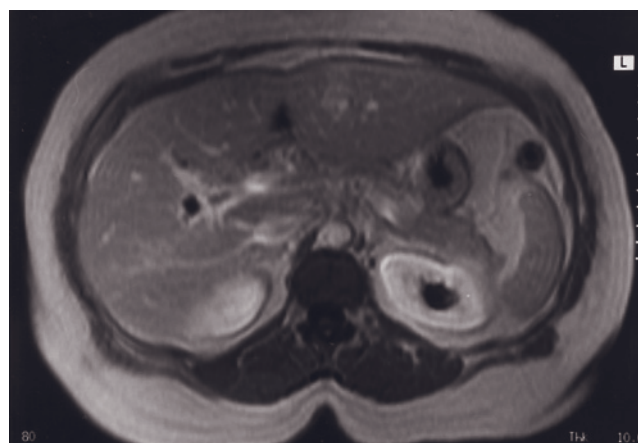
(Continued) an expansile thrombus (arrows, *a-c*) extending throughout the venous system. The thrombus demonstrates an increased signal intensity rim on T1-weighted images (*b, d, e*) and a small focus of increased signal intensity (arrow, *d*) within the thrombus, consistent with blood products at different stages of breakdown. Fat-suppressed postgadolinium images (*f, g*) demonstrate no evidence of enhancement within the thrombus. Thrombus is present in normal-caliber intrahepatic portal vein branches (arrows, *f*). Substantially increased enhancement of tissues surrounding the thrombosed SMV (arrow, *b*) suggests an underlying inflammatory process.
